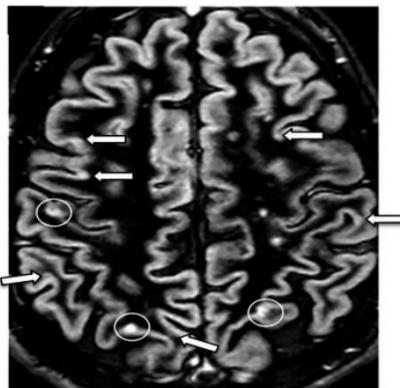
Axial DIR MRI of a brain with MS
